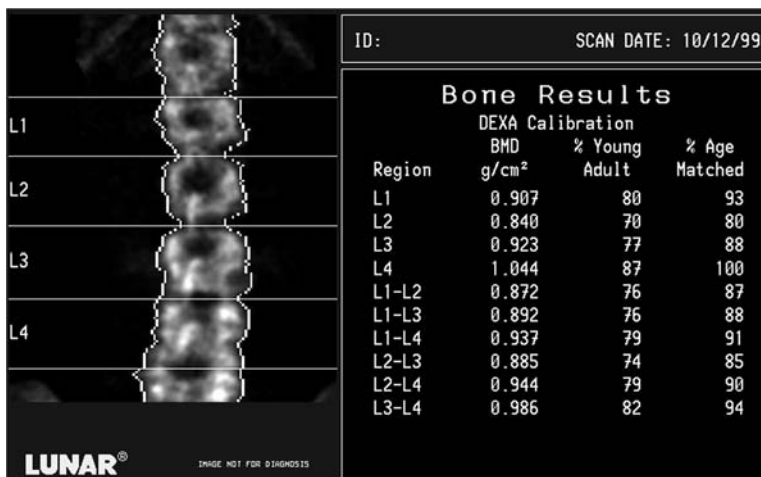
A DXA PA spine study acquired on the Lunar DPX. The vertebra labeled L4 has a classic block H or X shape. No ribs are seen, however, protruding from the vertebra that should be T12. It is far more likely that this represents five lumbar vertebrae with the lowest ribs on T11 than six lumbar vertebrae with the lowest ribs on T12. Also note that the BMD at L1 is higher than at L2, which is unusual. A lateral lumbar spine X-ray of this patient, shown in Fig. 2-9, confirmed a fracture at L1.
